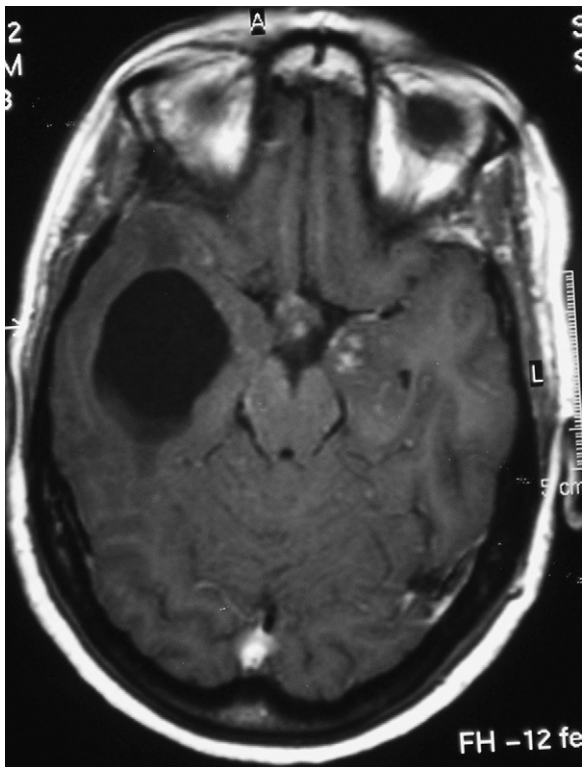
Axial MRI (T1 sequence with gadolinium). Cystic space-occupying process within the right temporal lobe corresponding to a trapped temporal horn. Note the granular enhancements in the left temporal lobe and the optic chiasm.
